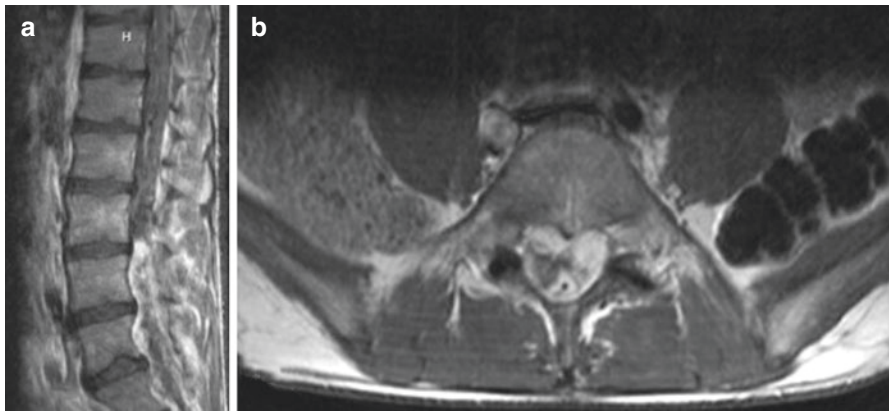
Sagittal (a) and axial (b) MRI showing a large expansile intradural mass in a 31-year-old man from L3–S2
